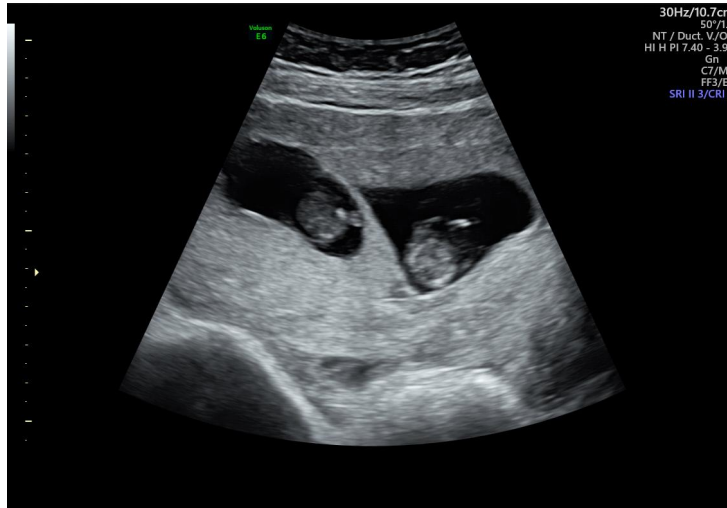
Twin Peak or Lambda Sign. Ultrasound (Transverse plane).
